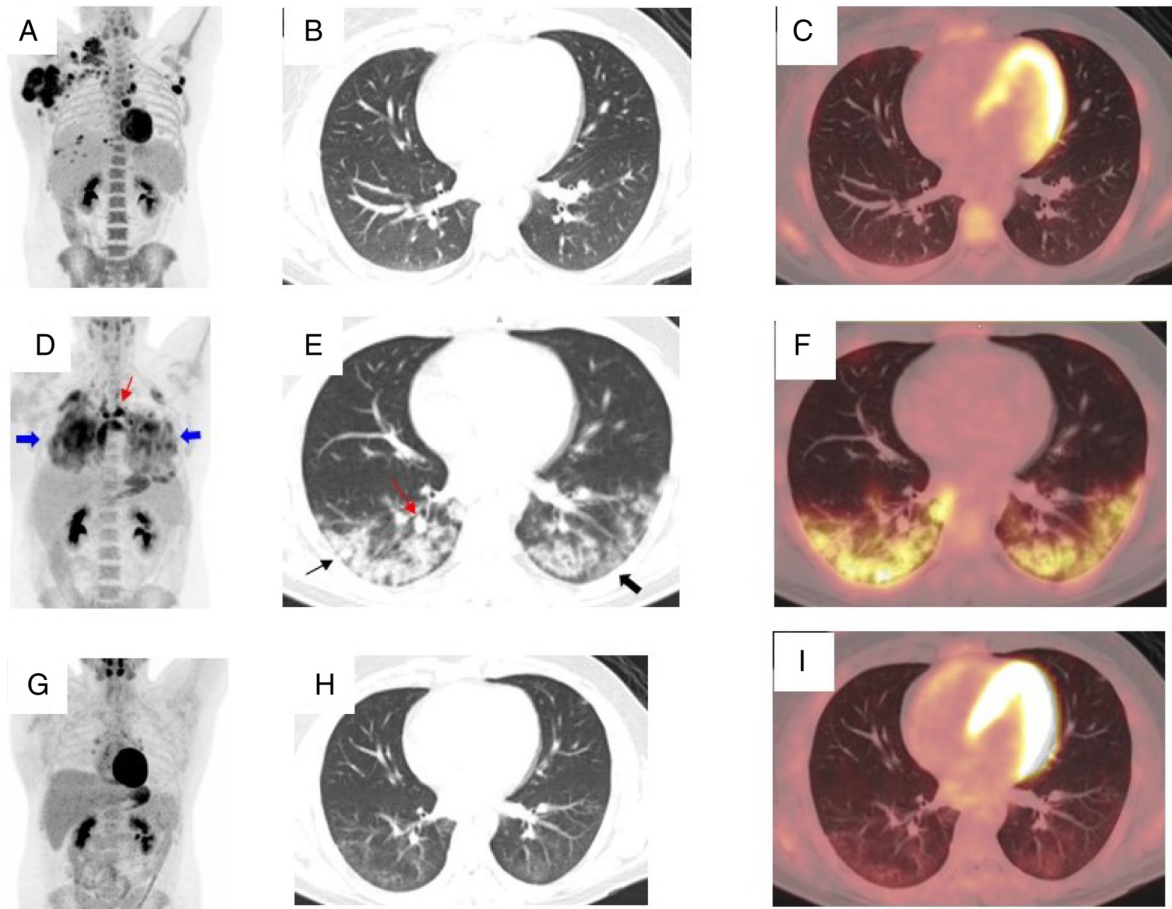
Incidental finding of COVID-19 pneumonia in a patient with lymphoma who presented for evaluation of lymphoma treatment. (A) MIP image of the initial staging  $^{18}\text{F}$ -FDG PET/CT demonstrated multiple hypermetabolic nodal lesions in the right axilla, right subpectoral region, left axilla and mediastinum, along with possible pleural metastases. (B) Axial CT and (C) hybrid PET/CT images were negative for pulmonary air space opacities. (D) MIP image showing interval decrease of FDG uptake in previously seen lymphadenopathy, suggesting good response to chemotherapy. However, there were diffuse increased FDG uptake in the bilateral lungs (thick blue arrow) and new foci of abnormal increased FDG uptake in the mediastinum (thin red arrow). (E) Axial CT and (F) hybrid PET/CT images of the chest demonstrated abnormal increased FDG uptake by numerous new pulmonary airspace opacities. The pulmonary opacities were bilateral, peripheral, multilobar, either ground-glass (thick black arrow) or consolidative (thin black arrow), and some with a rounded morphology (thin red arrow), which are all classic CT manifestations of COVID-19 pneumonia. (G) MIP image of follow-up FDG PET demonstrated interval decrease of diffuse abnormal FDG uptake in the bilateral lungs and foci of FDG uptake in the mediastinum. (H) Axial CT and (I) hybrid PET/CT images demonstrated interval resolution of residual FDG avid mediastinal lymphadenopathy and near complete resolution of previously seen FDG-avid peripheral pulmonary opacities, with very faint FDG uptake by the small residual ground glass opacities. (G, H and I) These images were acquired 2 month after the patient tested negative for COVID-19 and 1 month after two cycles of AVD.  $^{18}\text{F}$ -FDG PET/CT, positron emission tomography/computed tomography using fluorine-18-fluoro-2-deoxy-d-glucose; AVD, a chemotherapy combination that includes Adriamycin or doxorubicin, vinblastine, and dacarbazine or DTIC; MIP, maximum intensity projection.
